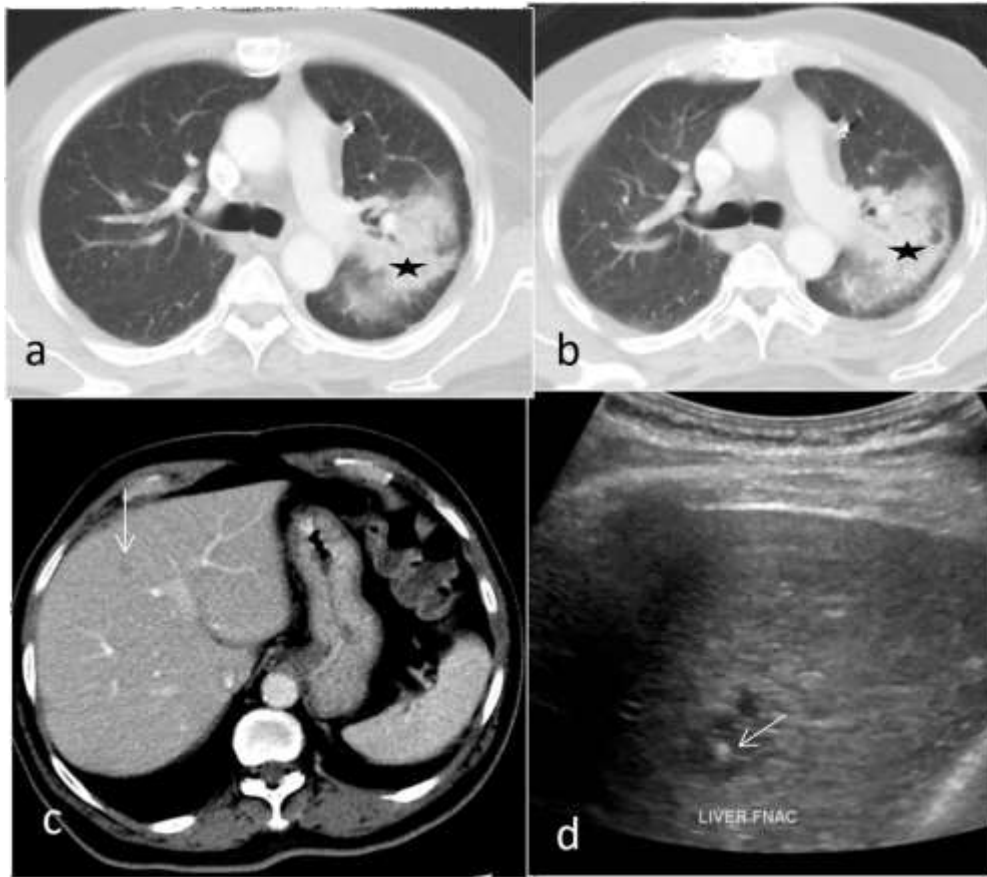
64 Y / Male patient, known case of carcinoma left lung (asterisk in a) on chemotherapy. Followup CT scan revealed stable left lung mass (asterisk in b), but developed new 8 mm liver lesion (arrow in c). USG guided FNAC of the liver lesion was done (arrow in d showing bright tip of spinal needle in liver lesion). Cytology report suggestive of metastasis.
